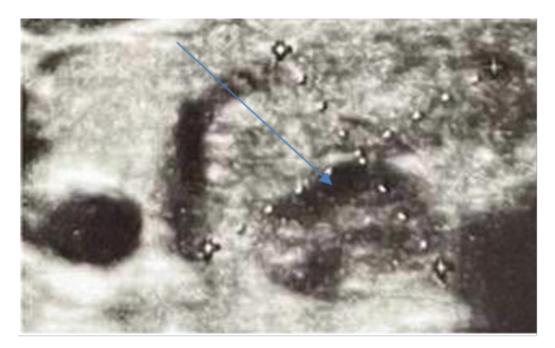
Preoperative neck ultrasonography image. The blue arrow indicates the nodule in the right lobe of the thyroid gland.
